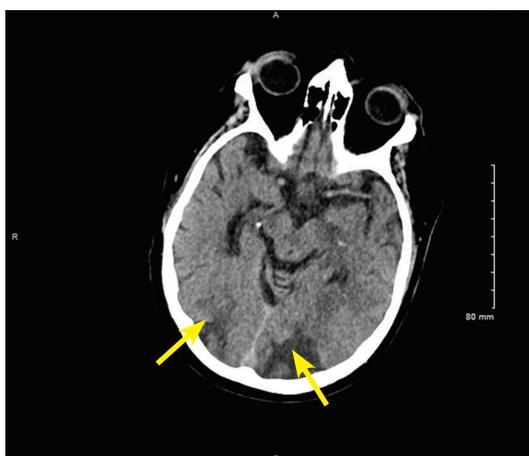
On hospital day 4, repeat CT imaging showed areas of hypodensity in both occipital lobes (arrows), indicating vasogenic edema.
